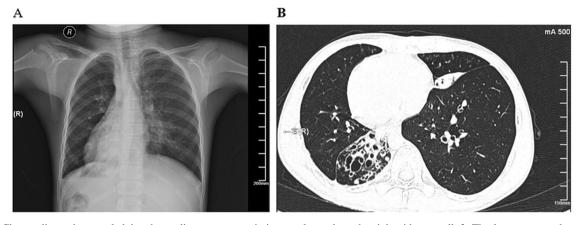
a Chest radiography revealed that the cardiac apex was pointing to the right, and both the aortic arch and the stomach bubble were
